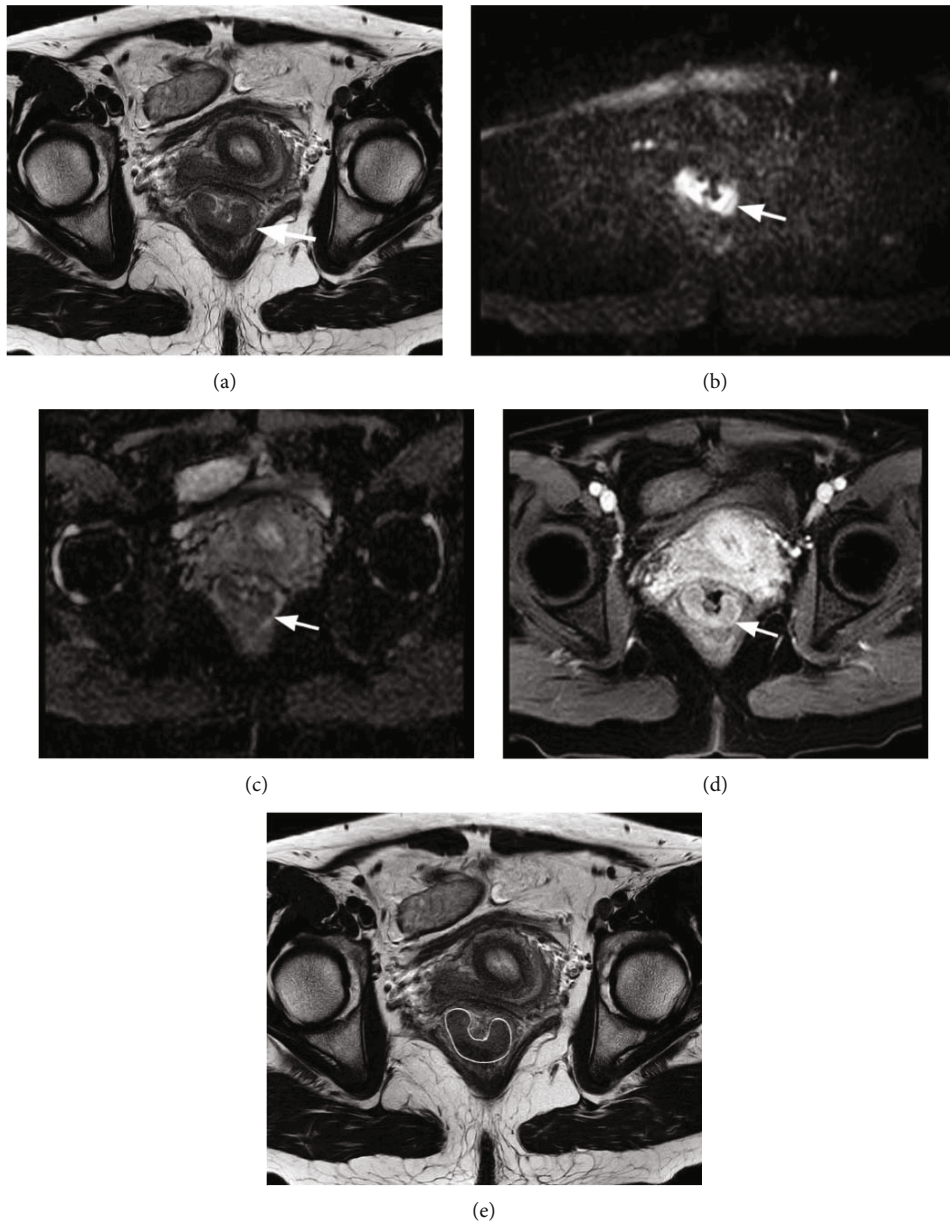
A 48-year-old woman with rectal adenocarcinoma was performed by IVIM and DCE. (a) High-resolution oblique axial T2W showed intermediate-signal intensity lesion (white arrow). (b) DWI ($b = 1000 \text{ s/mm}^2$) showed a hyperintensity lesion (white arrow). (c) ADC map showed a hypointensity lesion (white arrow). (d) DCE-MRI showed an abnormal enhanced lesion (white arrow). (e) ROI was manually drawn to cover as much of the entire tumor area as possible (white circle).
